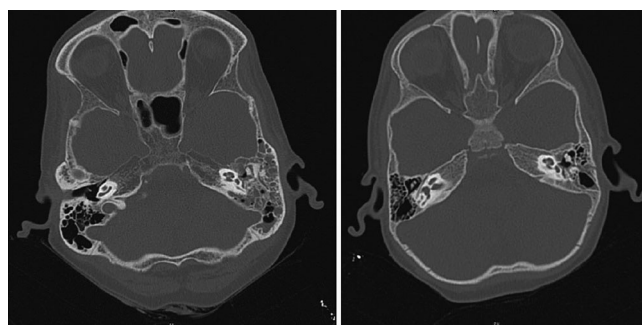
HRCT Temporal bone fluid collection in left mastoid and middle ear cavity without bony destruction suggestive of acute mastoiditis on Left side and longitudinal fracture of right mastoid bone with fluid collection in middle ear.
